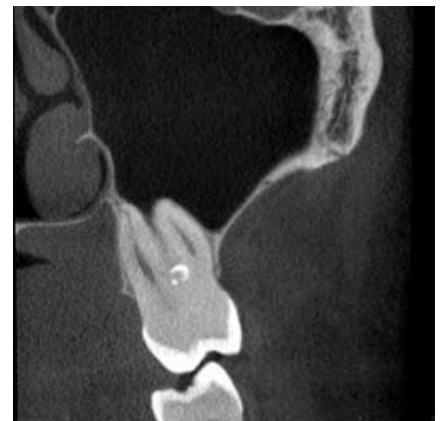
Coronal CBCT image
